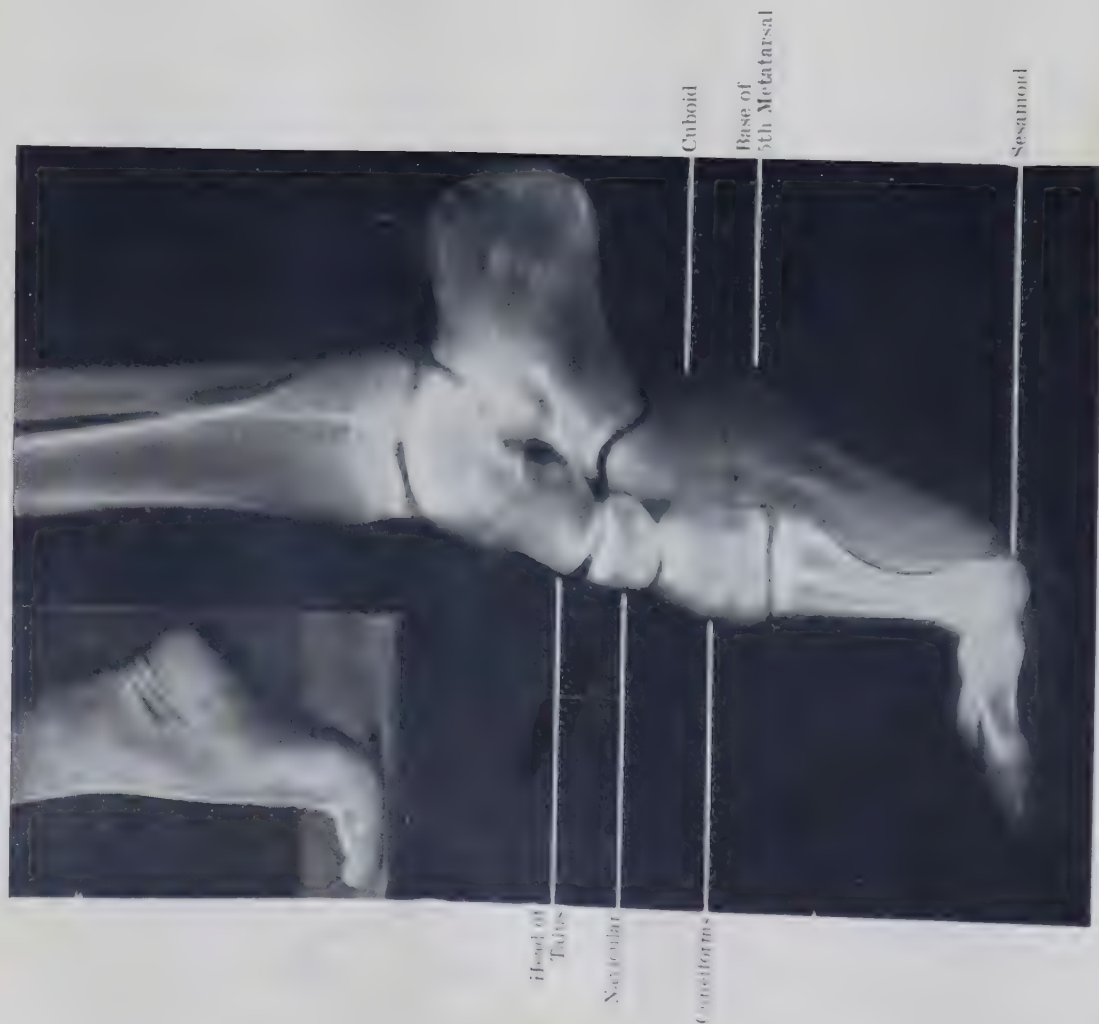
RADIOGRAPH OF RIGHT FOOT OF SUBJECT STANDING ON TOES (see inset).
